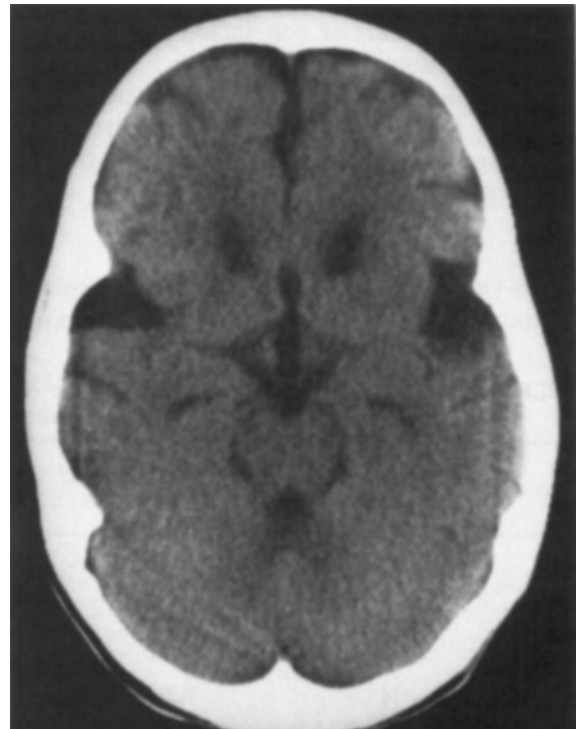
Computed tomography of a 16-year-old patient with glutaric aciduria type I demonstrates central and cortical atrophy. The changes are most prominent at the caudate head and in the insular region.
